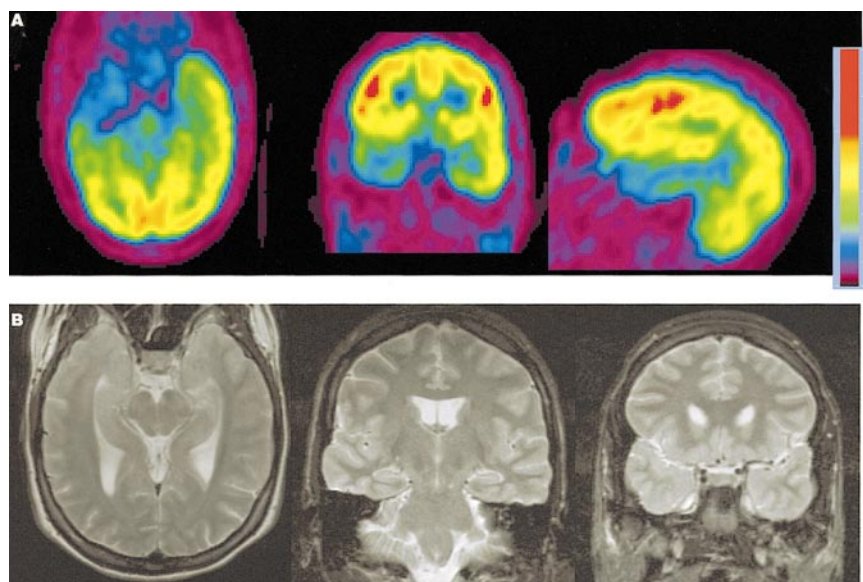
(A) From left to right, axial (plane of acquisition) and reformatted coronal and sagittal FDG PET images from 39-y-old man with medically refractory right TLE show prominent focal hypometabolism anteromesially in right temporal lobe. (B) MR images show no significant abnormalities.
